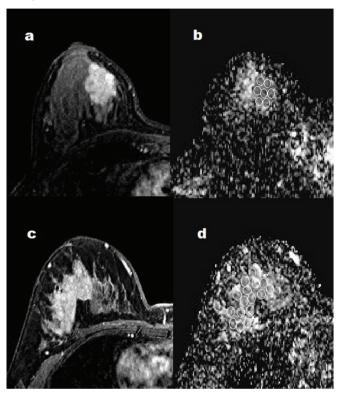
(a, b) The DCE-MR image of a 32-year-old patient with a diagnosis of invasive ductal carcinoma shows an enhancing mass in the right breast. ADC measurement was made from its counterpart on the ADC map. (c, d) The DCE-MR image of a 37-year-old patient; the biopsy result of the NME in the right breast is DCIS. Multiple ROIs were measured from this lesion, which displayed a low signal intensity on the ADC map
